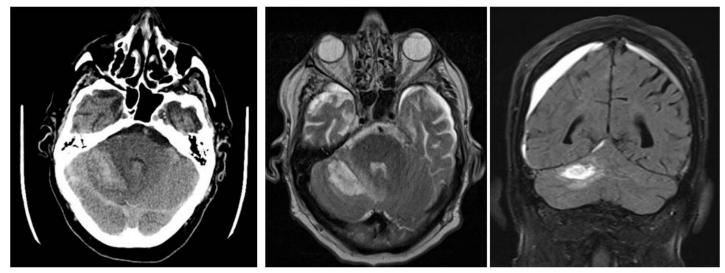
Postoperative axial non-contrast computed tomography scan and axial and coronal brain magnetic resonance imaging revealing Chronic subdural hematomas predominate on the right, extending to the tent of the cerebellum on the right and the tent of the brain on the left with a discrete mass effect on the cortex and the right lateral ventricle without deviation of the median line or hydrocephalus.
